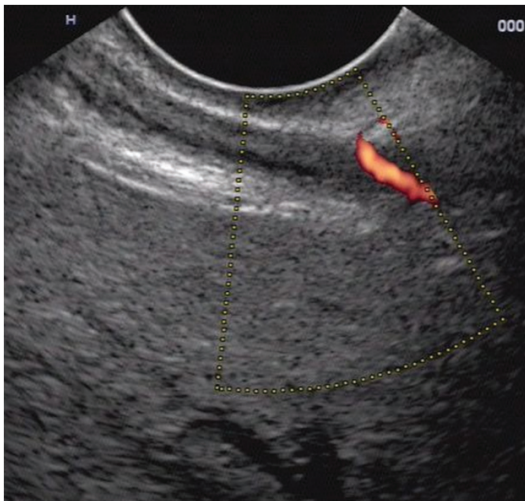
EUS: perforator vessel on power Doppler
